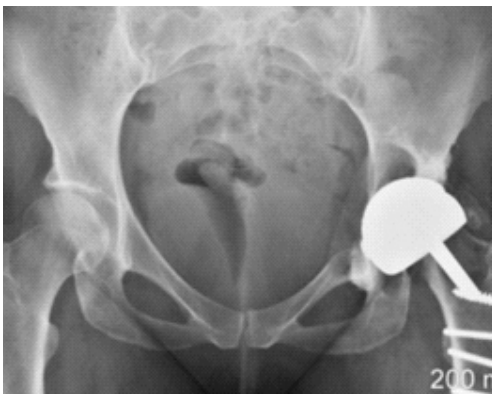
Anteroposterior plain radiograph demonstrates radiographic features of osteolysis around the acetabular and femoral components.
